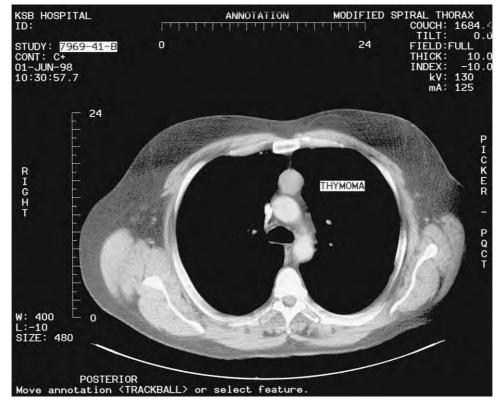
Computed tomographic scan of the chest showing thymoma.
